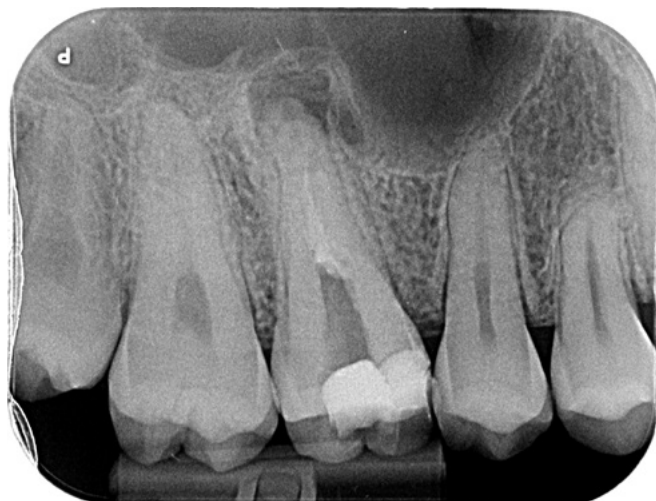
An initial radiographic examination revealed only a single vestibular canal, with the apex appearing open.
